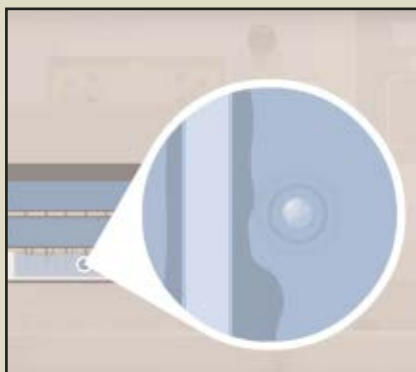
Ultrasonic waves effectively destroy protein and salt deposits inside and outside of manifold tube walls.
